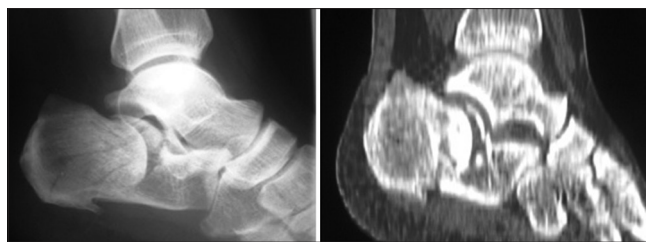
Preoperative X-ray (left) and computed tomography scan (right): displaced articular fracture of calcaneus
